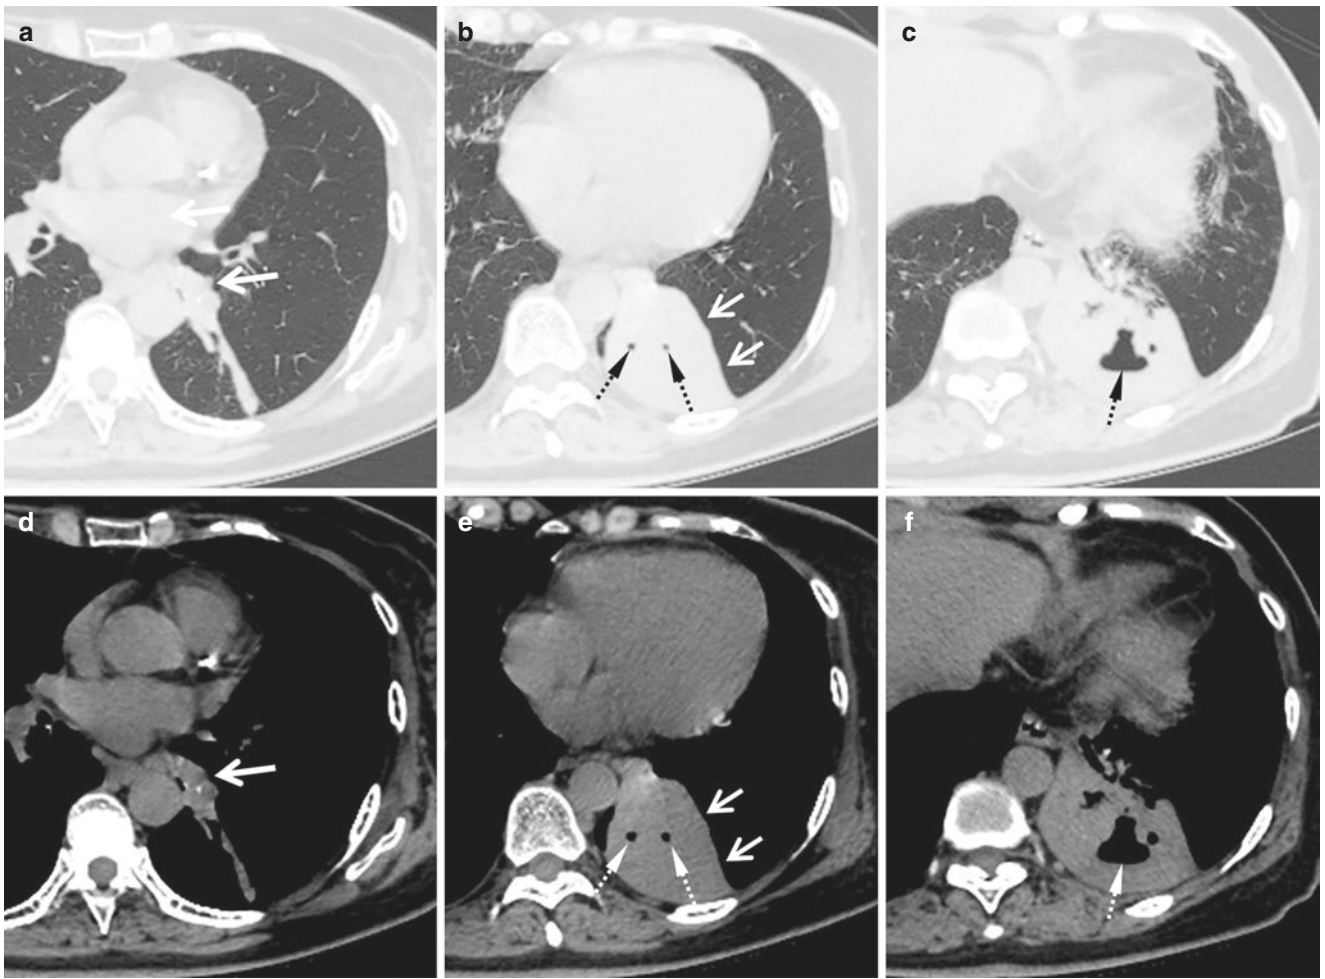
The chest CT image after anti-infective therapy. (a–c) are axial CT images with lung window at different level in the left lower lung, (d–f) are the corresponding CT images with mediastinal window
